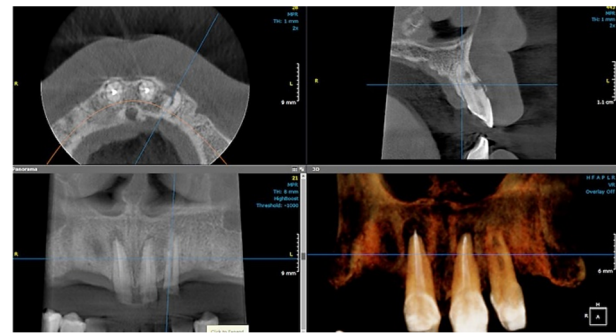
CBCT exposing the presence of the two distinct lesions, the lateral extension of the resorption; the penetration of the lesion into the root canal and the extension under the alveolar crest. CBCT: Cone-beam computed tomography.
